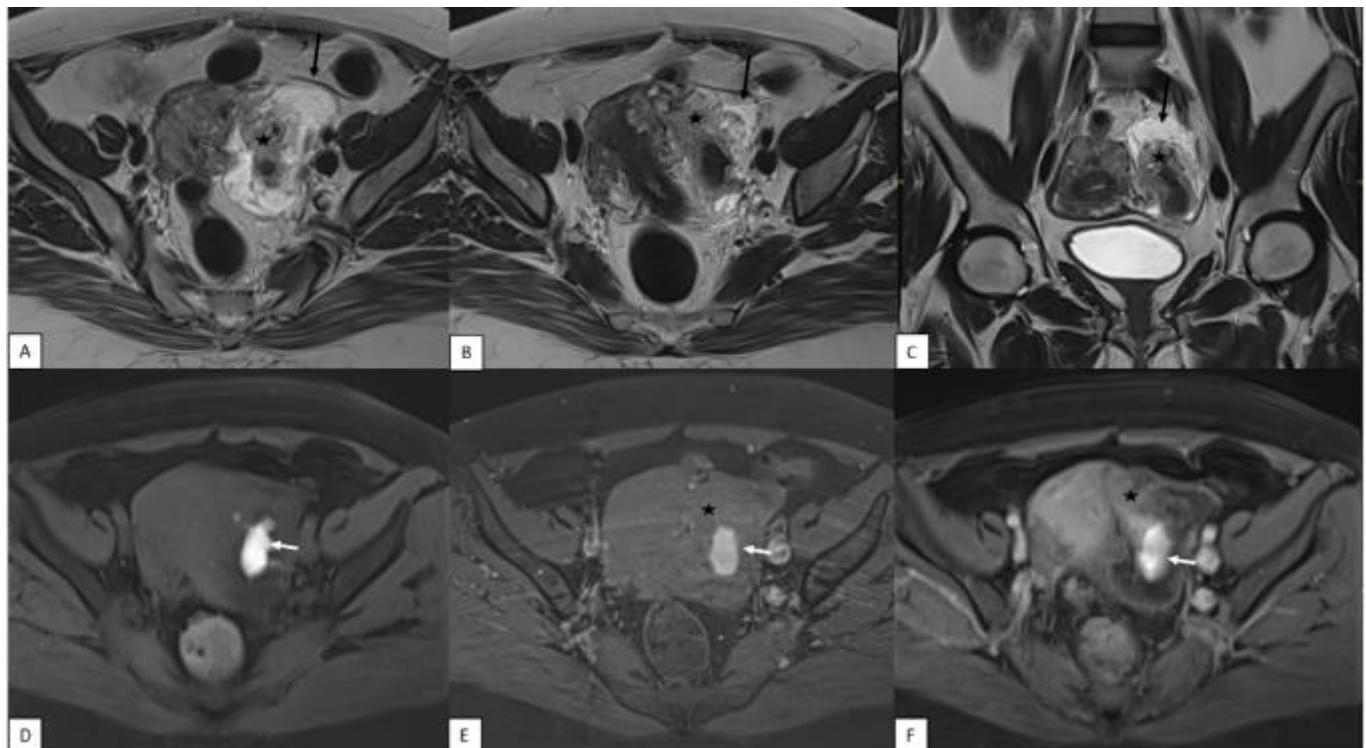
Magnetic resonance imaging (MRI) demonstrates a left latero-uterine mass with heterogeneous signal intensity on T2-weighted sequences (A-C), containing hemorrhagic areas on T1-weighted sequence (D), and showing contrast enhancement after gadolinium administration (E, F)
